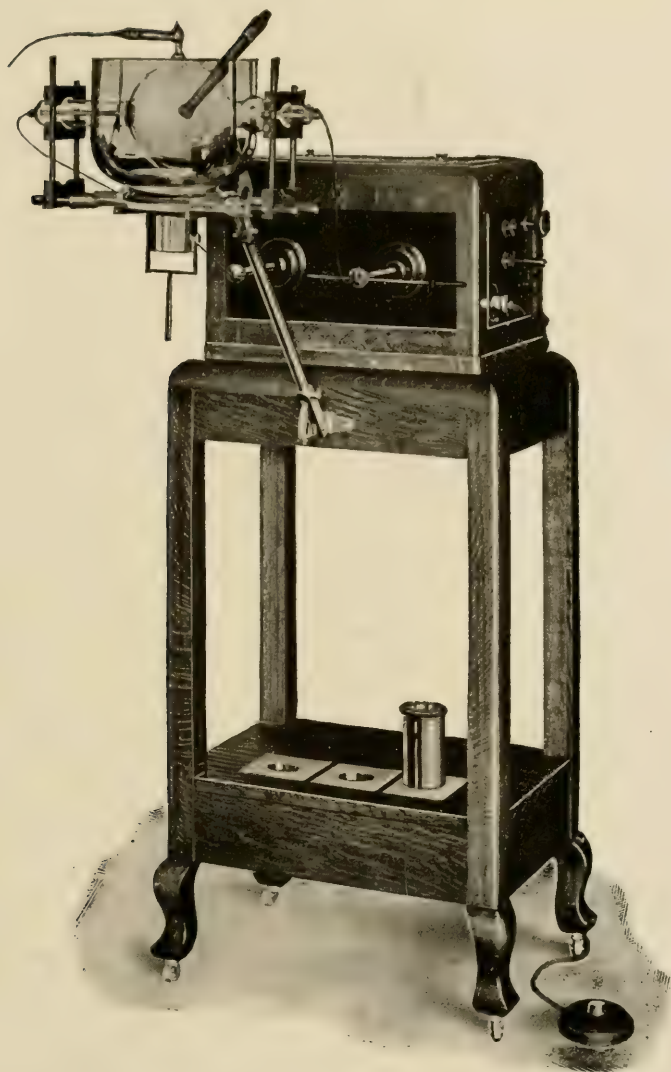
Special dental X-ray machine. High-frequency coil type. Size: 24 inches wide, 16 inches deep, 52 inches high.
